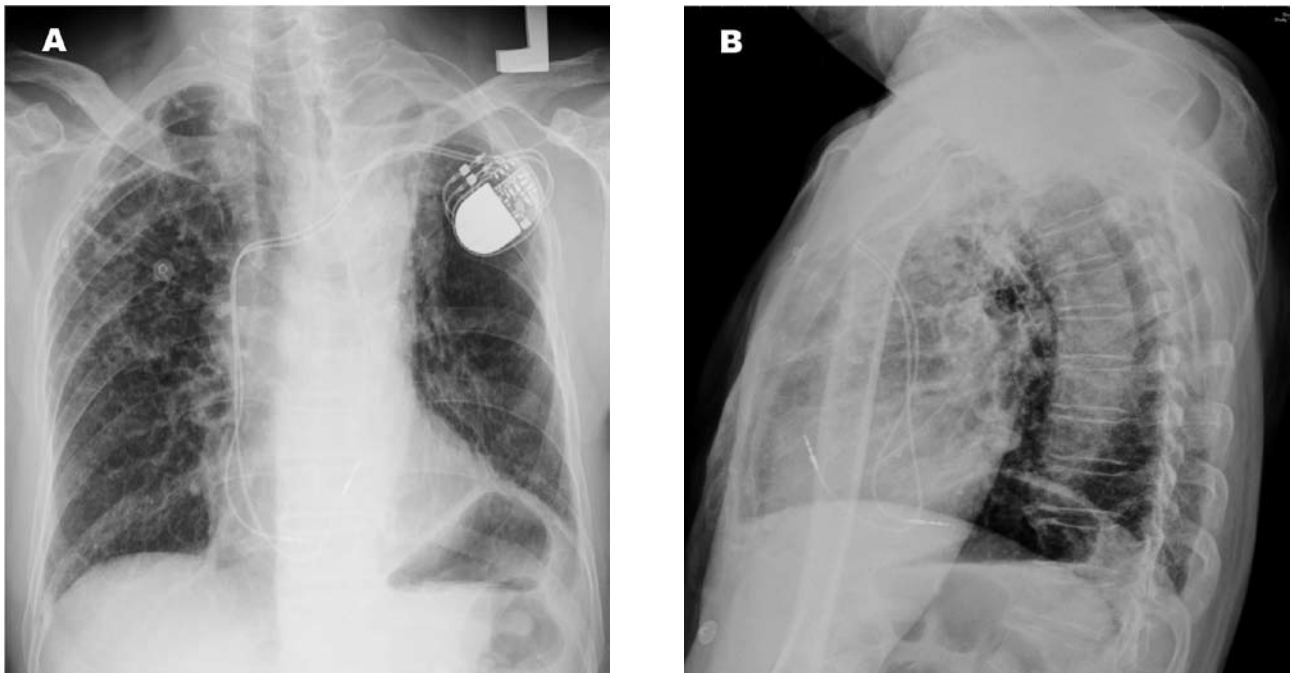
Postoperative chest x-ray in posterior-anterior (A) and lateral (B) view.
